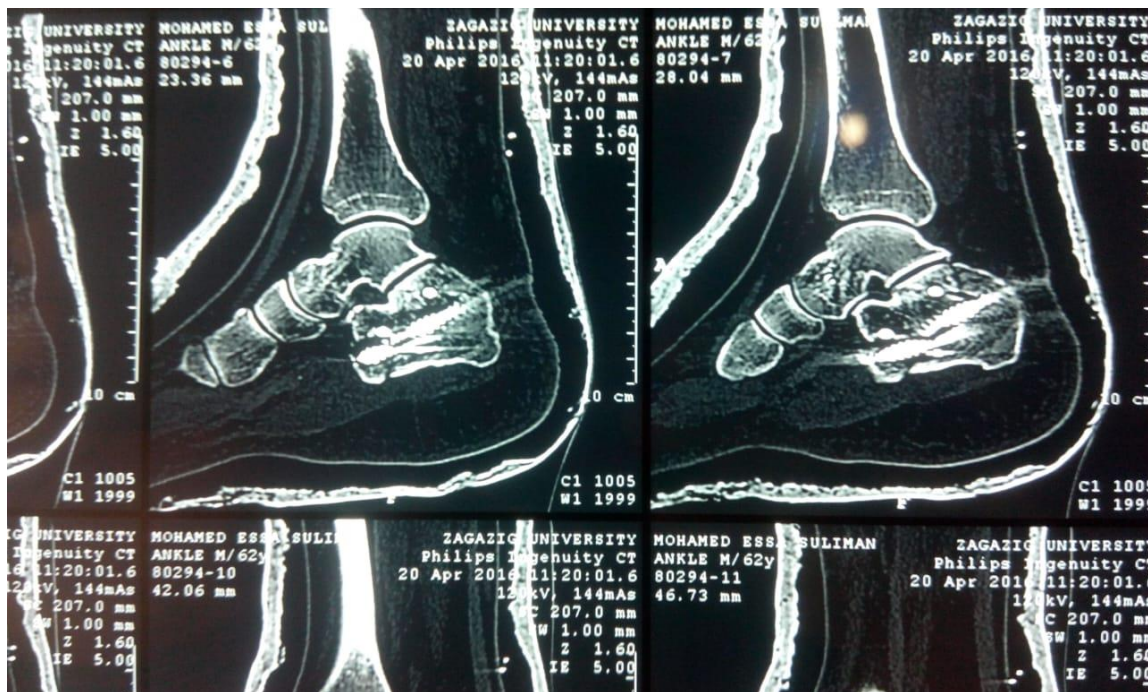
post opetative CT scan with adequate restoration of articular surface.
